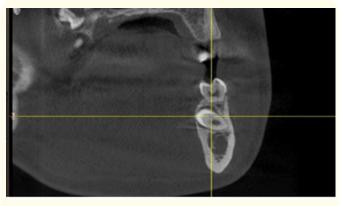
CBCT section of the previous image showing the lingual eruption of 4.5.
